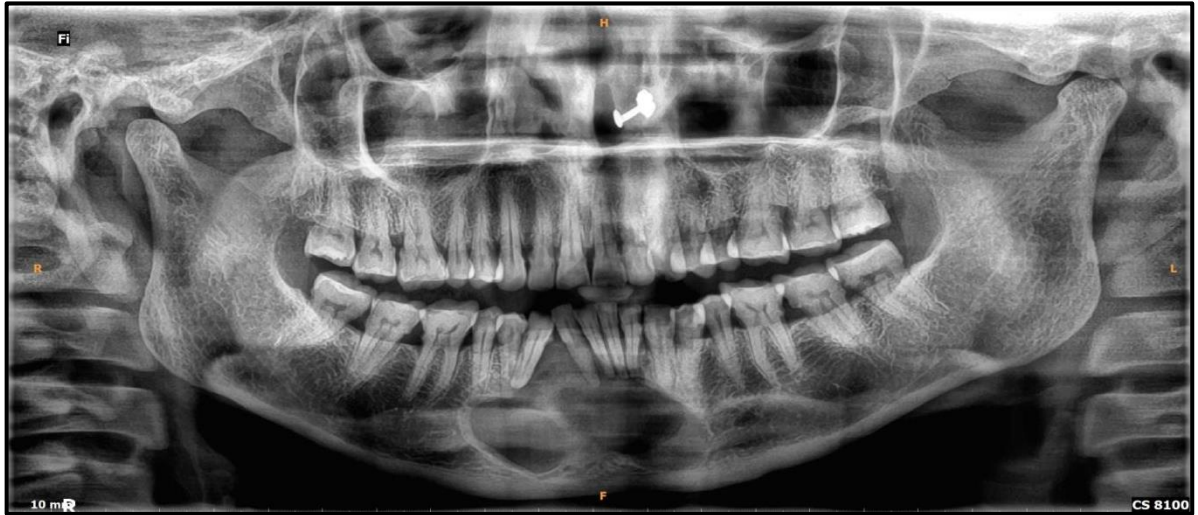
Panoramic radiograph show multilocular radiolucency, roughly oval in shape. on closure look calcification was observed in multilocular area
